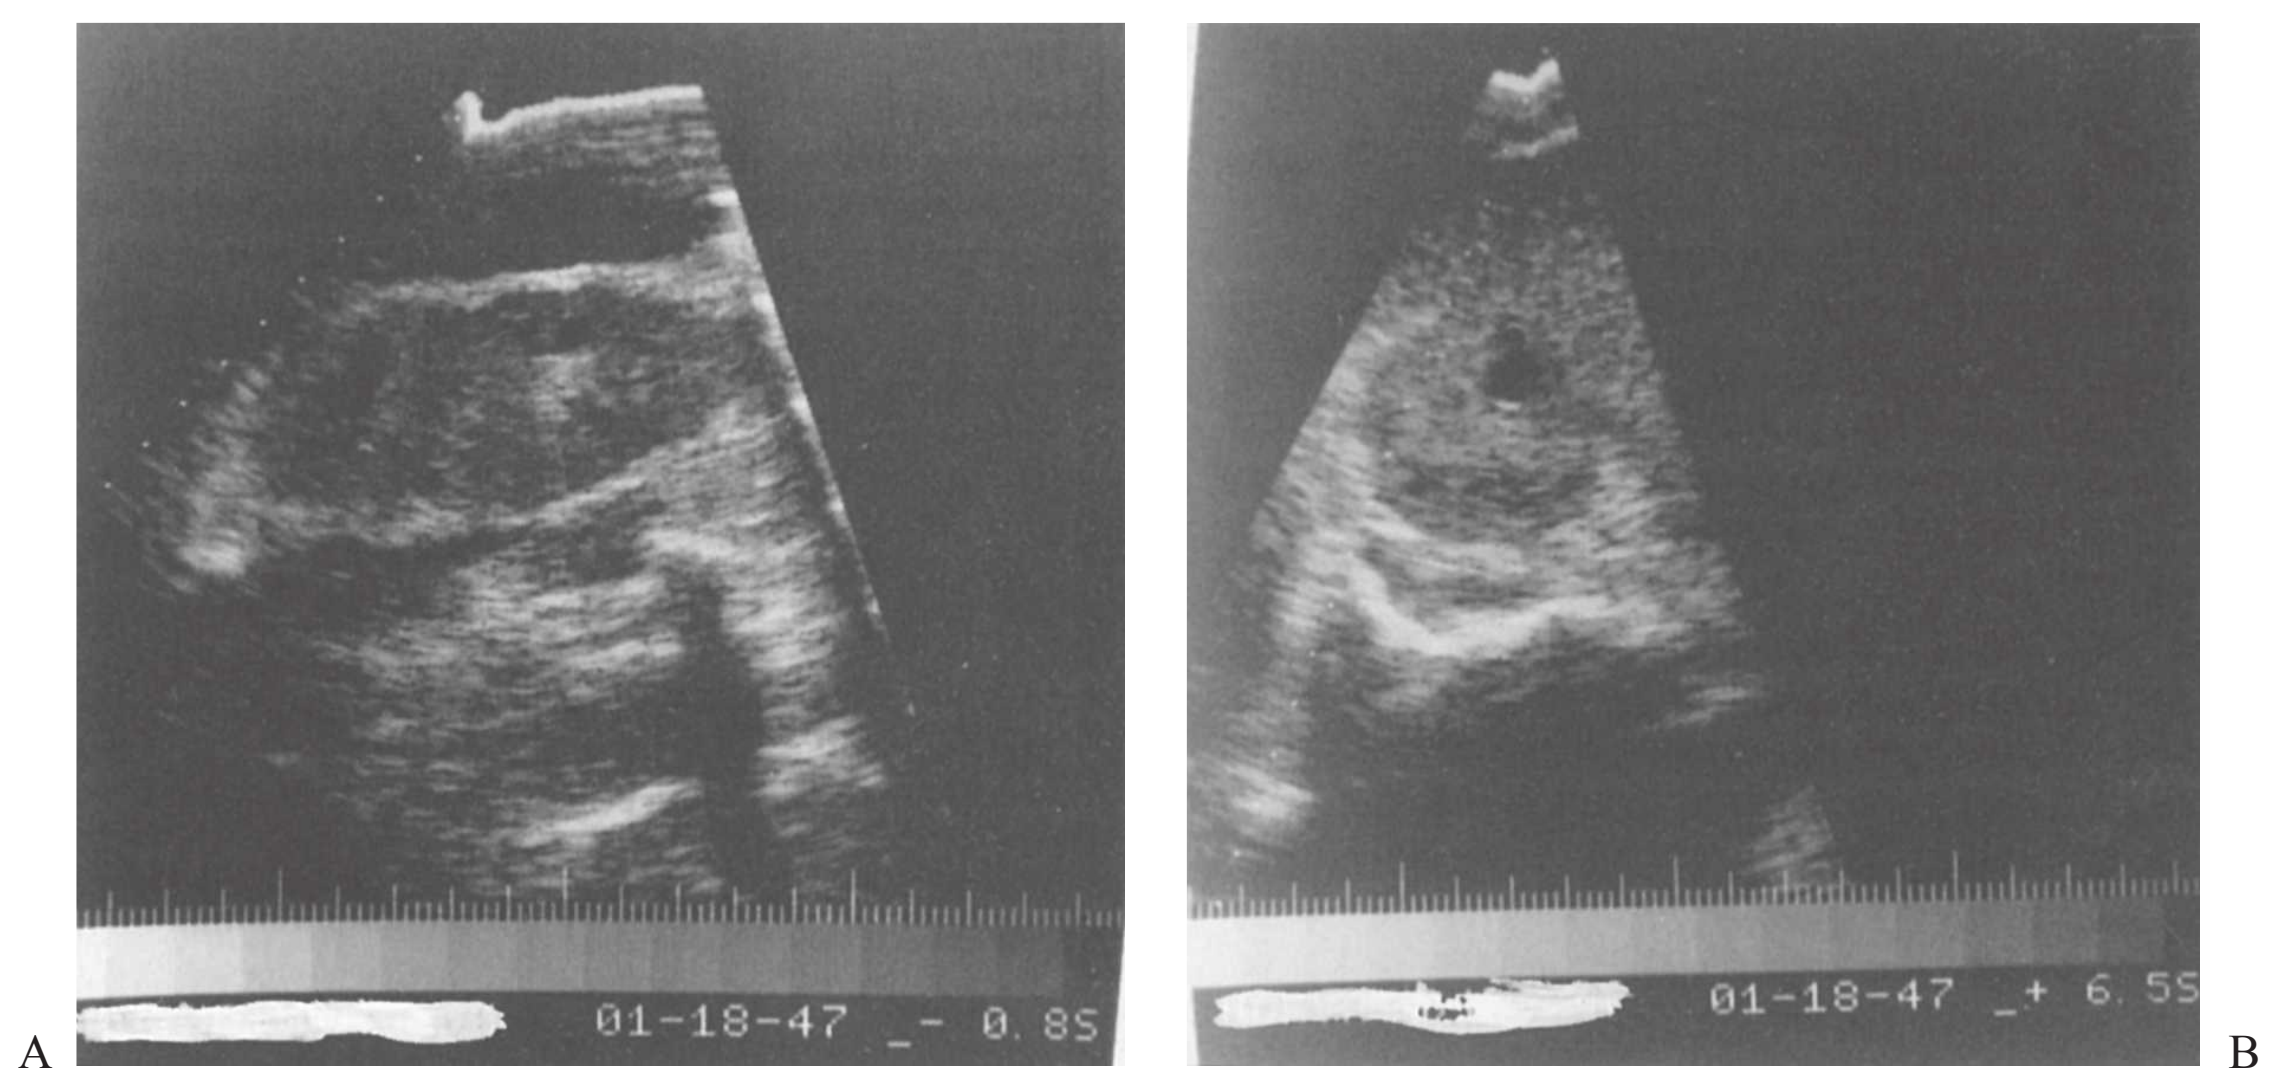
Ultrasonogram of the right kidney after 4 weeks of antibiotic therapy (from the same patient as in Fig. 24.2). Longitudinal view (A) and transverse view (B) showing a decrease in the size of the fluid-filled echolucent lesions. (From Andriole VT. Renal carbuncle. *Medical Grand Rounds*. 1983;2:259, with permission.)
